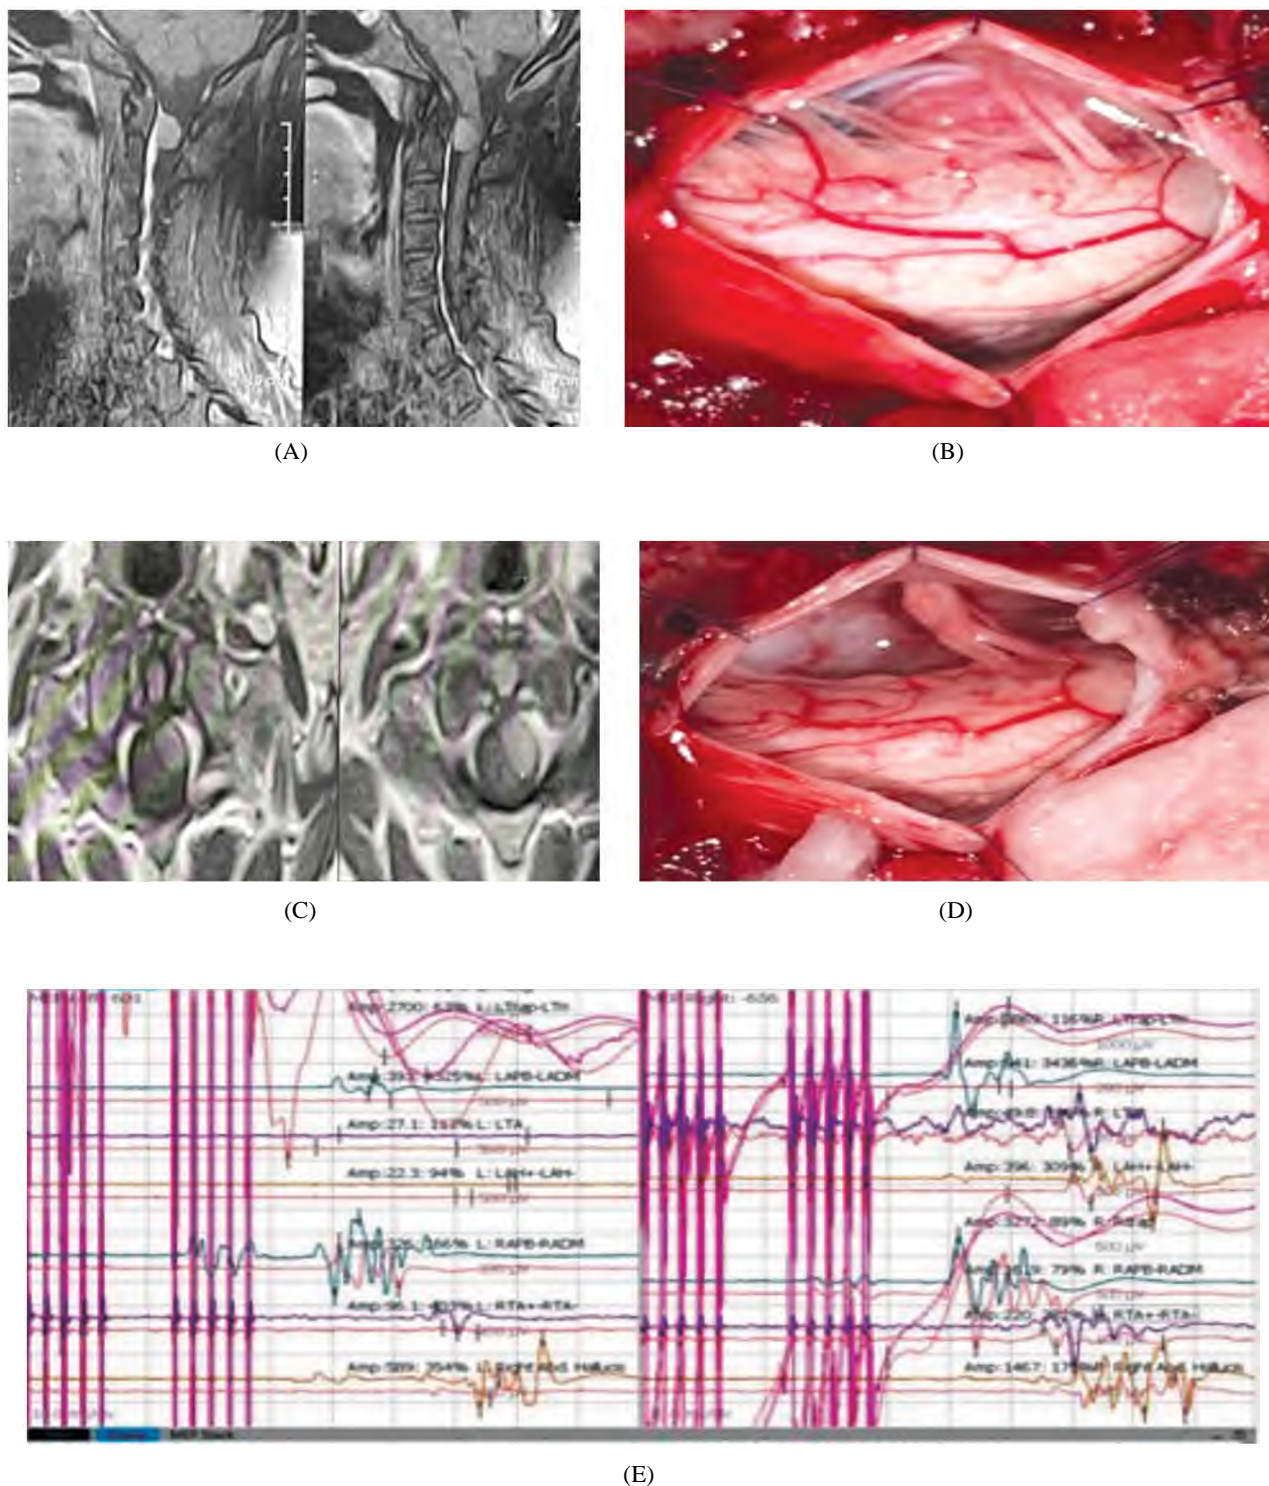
A case of cervical meningioma, gross total resection was achieved using IONM techniques without any intraoperative MEP or SSEP alarming changes, patient recovered well without post-operative deficit. (A, C) Cervical spine MRI with contrast showed well defined homogeneously enhancing lesion at the level of C1 - C2 located left anterolaterally pushing the cord to the right. (B) A screenshot during intraoperative IONM. (D, E) Pre and post resection photos which revealed gross total resection.
